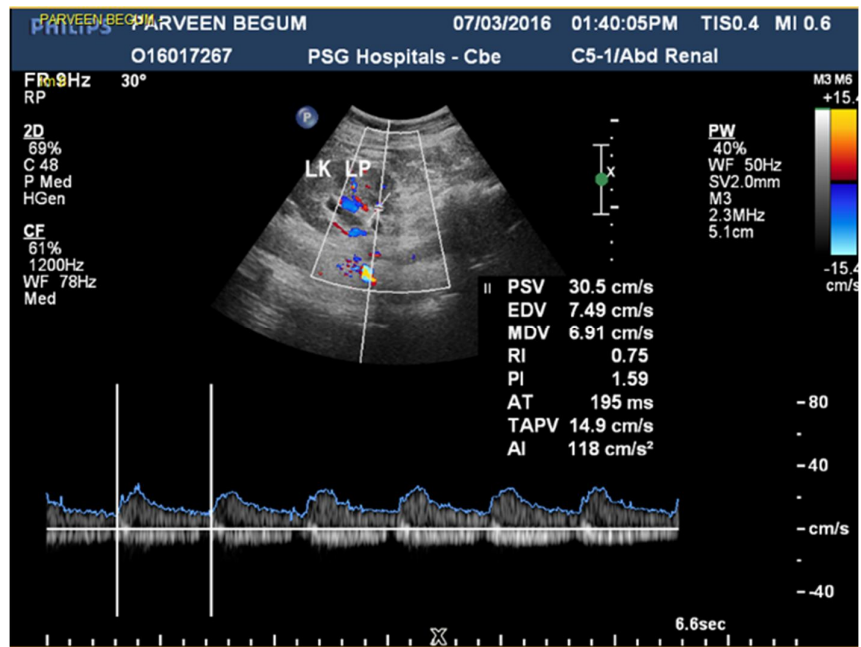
(C) Doppler US demonstrating an RI value of 0.75 in the lower pole of left kidney (obstructed kidney)
